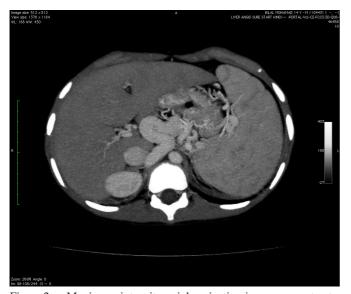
Maximum intensity axial projection image on contrast–enhanced CT scan showing a large porto-caval shunt extending from the origin of portal vein to the intrahepatic IVC, measuring 15 mm.
